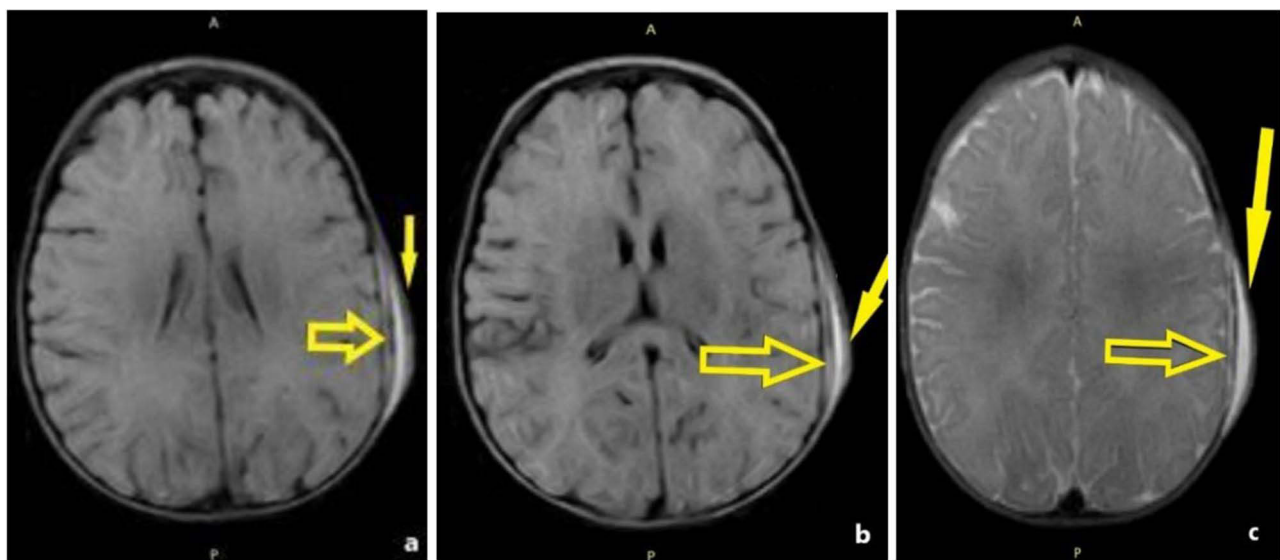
5-month-old baby fell from 2 feet. (a and b) Left-sided parietal subdural hematoma (yellow arrow)- A crescent-shaped collection with high-intensity FLAIR signal; hyperintense epicranial left parietal hematoma (yellow arrow) on FLAIR. (c) isointense T2 signal; T2-weighted imaging epicranial left parietal hematoma (yellow arrow).
